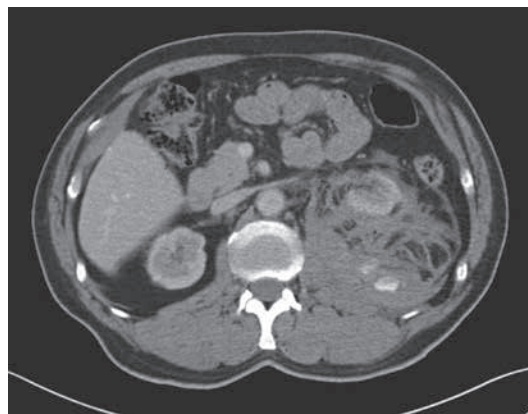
CT-scan after intravenous contrast in venous phase: visualisation of a large left-sided perinephric hematoma and contrast extravasation within the hematoma.
